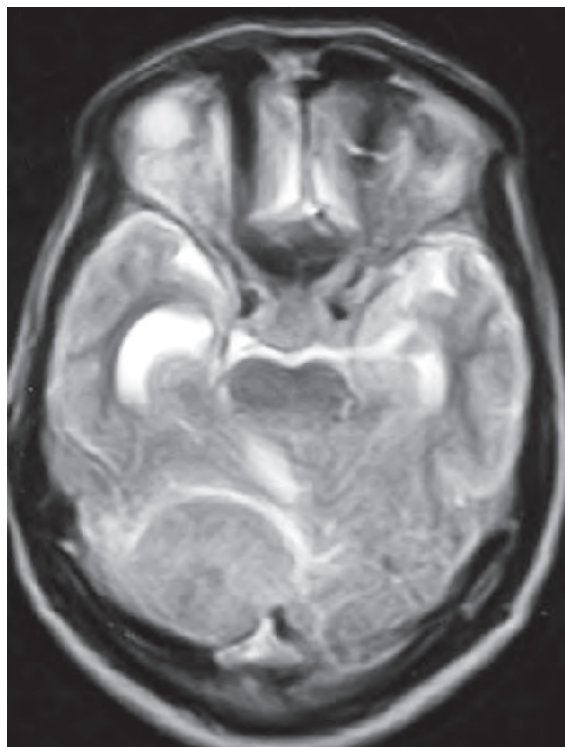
Axial T2-weighted MR image showing a torcular meningioma in the supratentorial compartment. This lesion was excised using an occipital craniotomy
